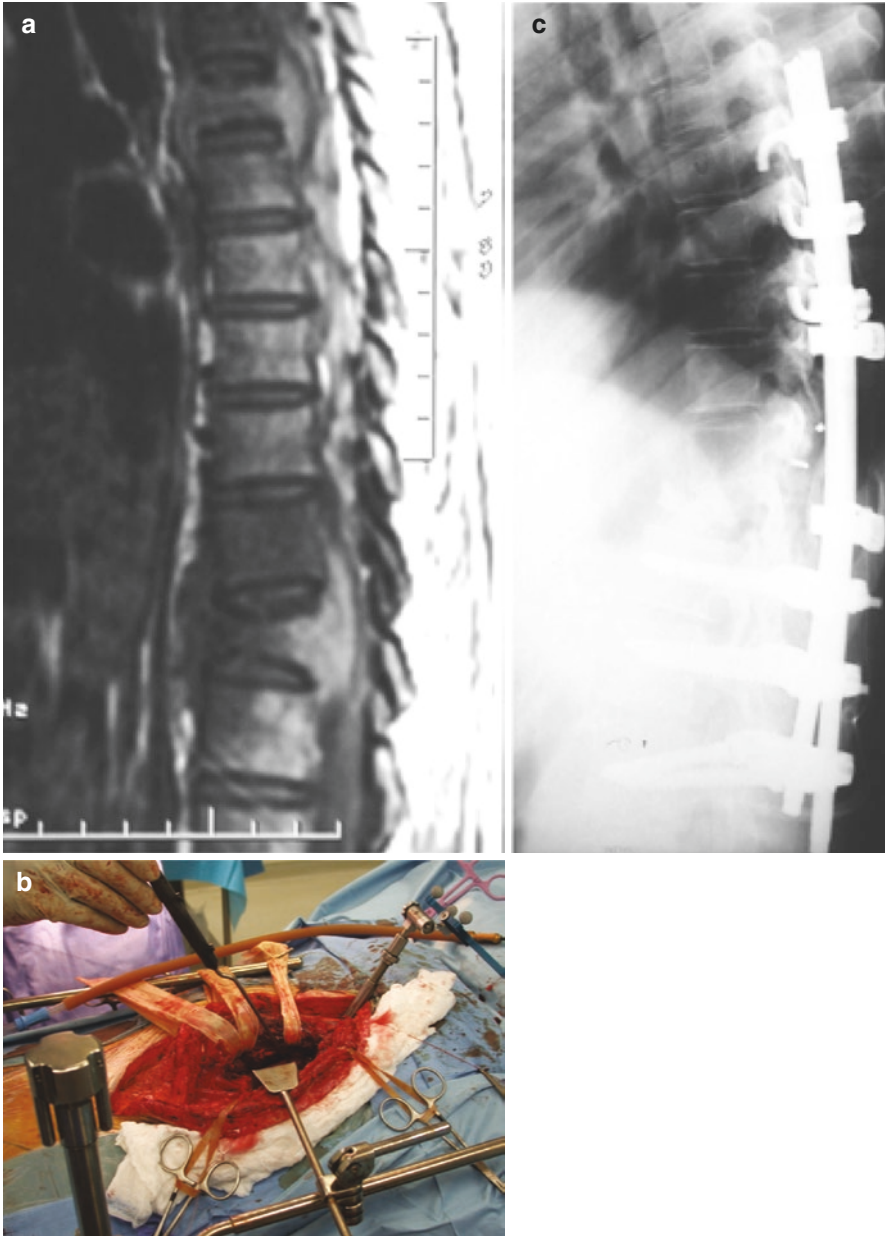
(a) Preoperative image of a 24-year-old patient with Pott's disease of the spine. Image shows vertebral body involvement and collapse, as well as extension of infectious phlegmon to the ventral epidural space causing spinal cord compression. (b) Intraoperative photograph of the lateral extracavitary approach to the spine. (c) Postoperative plain films showing posterior instrumentation placement
